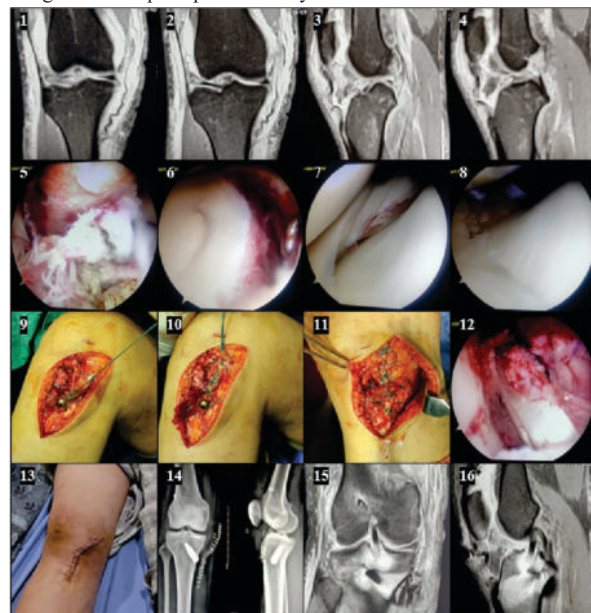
Images 1-4 are of pre-operative MRI scan showing tibial spine avulsion fracture, altered interstitial signal of ACL, complete tear of medial collateral ligament, peripheral detachment of medial meniscus and tear of patellar tendon. Image 5 shows arthroscopy findings of displaced tibial spine avulsion fracture and bruised-torn ACL. Image 6 shows arthroscopy findings of red-red zone tear of medial meniscus, tear of MCL and peripheral separation of medial meniscus from the MCL-capsular attachment. Image 7 shows arthroscopy finding of tear of lateral meniscus. Image 8 shows arthroscopy picture after excision of posterior horn tear of lateral meniscus. Images 9-11 show interference screw holding the STG graft of reconstructed ACL in the tibial tunnel, repaired patellar tendon, and open repair of MCL with its reinforcement by suturing the end of STG graft on to it. Image 12 shows arthroscopy picture of reconstructed ACL. Image 13 shows the wound closure. Image 14 shows post-operative x-ray after ACL reconstruction. Image 15-16 show post-operative MRI scan after ACL reconstruction.
